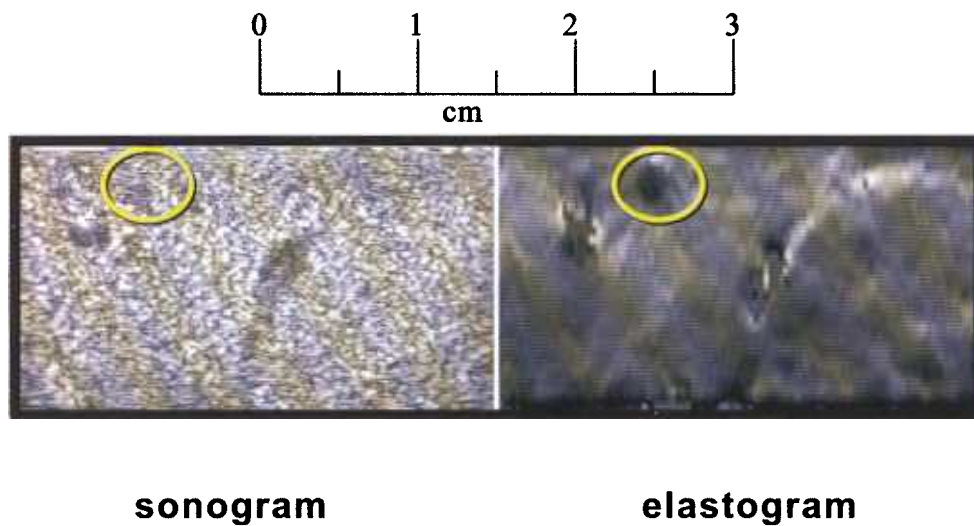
Rabbit liver in vivo, bearing a 3 mm thermal lesion. Note the good contrast between the stiff lesion and the embedding normal liver in the elastogram, and the lack of echo contrast in the sonogram. The sonograms were taken with a Philips/ATL HDI-1000 scanner at 7.5 MHz (Merritt et al., 2002).
